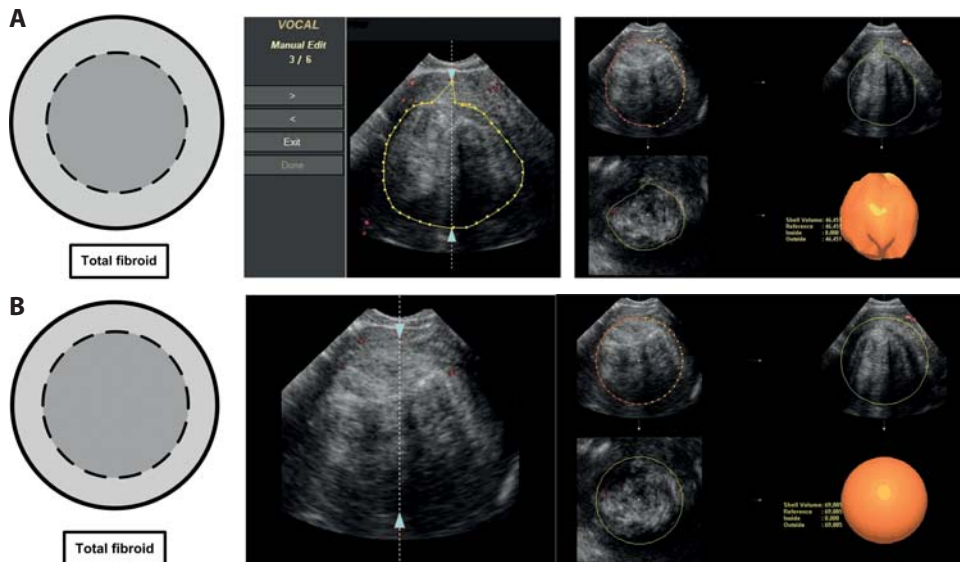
Method of fibroid volume calculation using 3D Power Doppler. In both the automatic sphere contour (2b) and manual contour (2a) mode rotation steps of 30 degrees were used (6 different planes). The poles were placed at the boundaries of the fibroid. For the manual contour, the circumference of the fibroid had to be drawn manually in each of the total six planes. A 3D rendering image of the fibroid and its calculated volume is seen in the lower right part of both figures.
